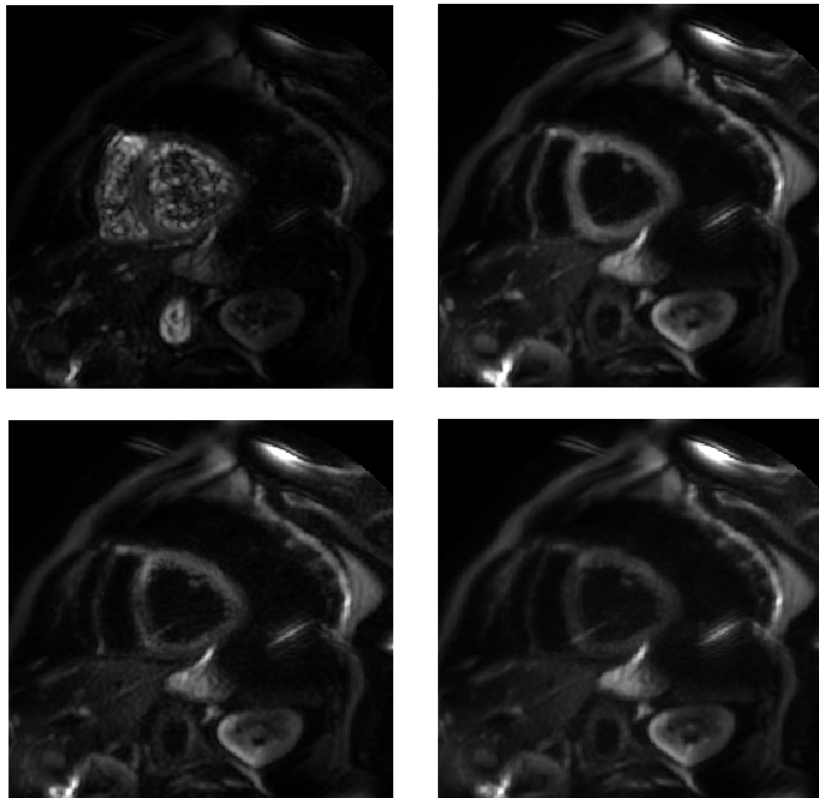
Axial slices of DWI acquisition in a healthy patient for b -values of 0, 50, 150 and 300 s/mm^2 (from upper left to bottom right).
